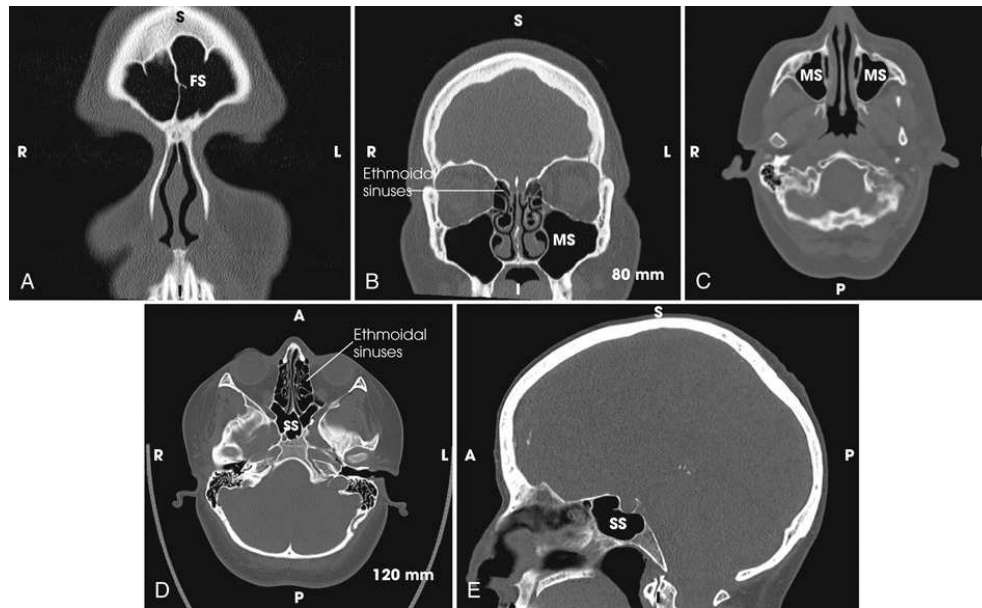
(A) Coronal CT image of frontal sinuses (FS). (B) Coronal CT image of ethmoidal and maxillary sinuses (MS). (C) Axial CT image of MS. (D) Axial CT image of ethmoidal and sphenoid sinuses (SS). (E) Sagittal CT image of SS. Courtesy NEA Baptist Memorial Hospital, Jonesboro, AR.
